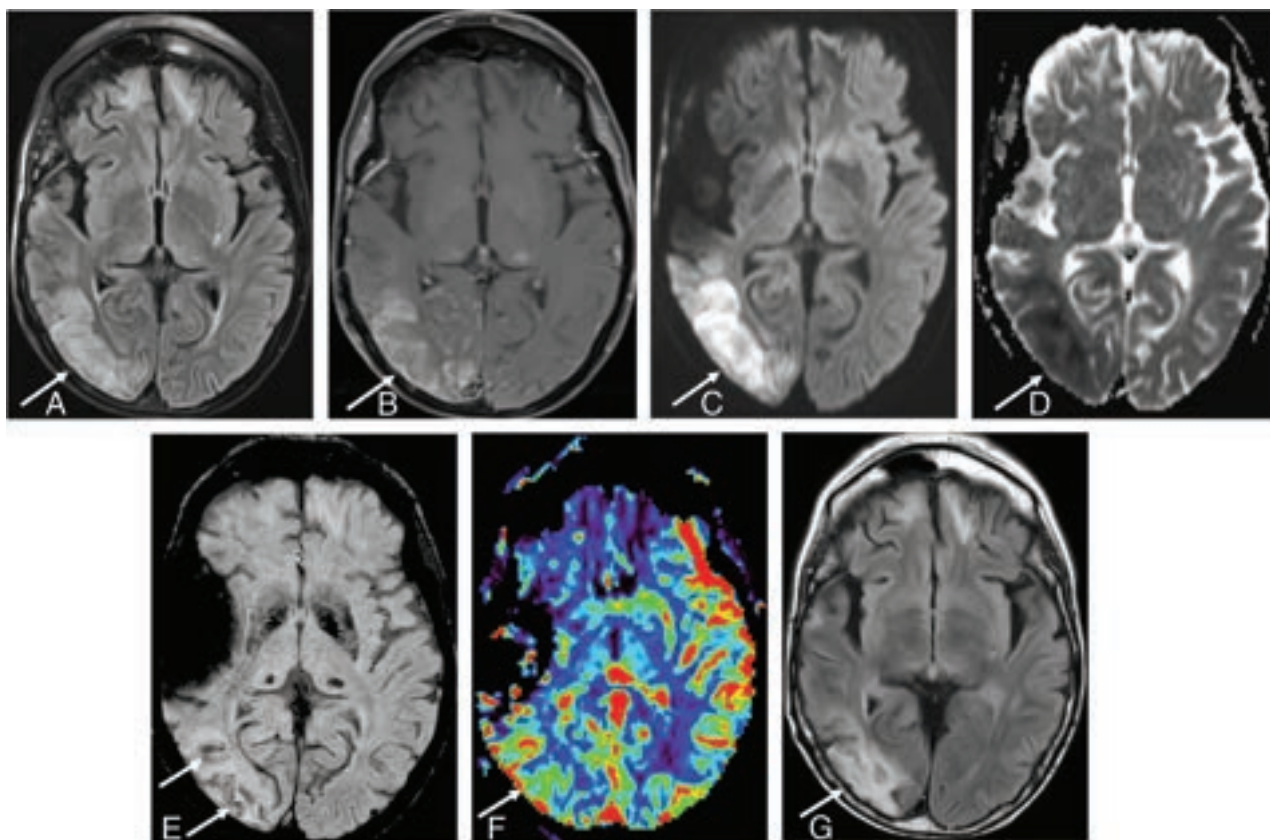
A 50-year-old man diagnosed with SMART syndrome. He had a history of pilocytic astrocytoma treated by resection and 60 Gy of radiation therapy 30 years ago and presented with left-sided hemiparesis, speech impairment, seizure, and migraine-like headache. He was diagnosed with SMART syndrome and treated by verapamil and aspirin, but residual symptoms (hemiparesis and speech impairment) remained. *A*, A FLAIR image shows cortical hyperintensity and involvement of subcortical white matter in the right temporo-occipital region (*arrow*). There is bifrontal subcortical white matter hyperintensity likely due to prior radiation injury. *B*, There is gyriform enhancement in the right temporo-occipital region (*arrow*) with restricted diffusion (*C* and *D*) (high signal on DWI and low signal on ADC) (*arrow*). *E*, SWI shows linear hypointensity along the subcortical white matter (*arrow*). *F*, Dynamic susceptibility contrast perfusion MR imaging shows an increase of CBV in the same area. *G*, After 3 months, FLAIR shows residual hyperintensity in the cortical and subcortical area (*arrow*).
